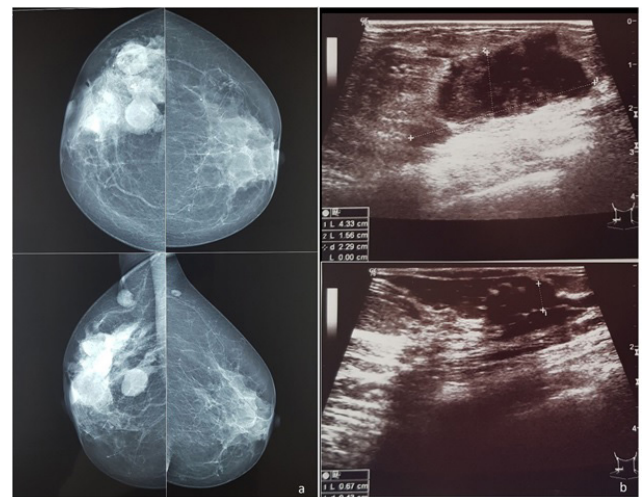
a. Mammography showing multiples round opacities with regular contours associated with macro-calcifications of right breast, Normal left mediolateral oblique mammogram for comparison b. Breast ultrasound showing hypoechoic areas in the upper quadrants of the right breast.
